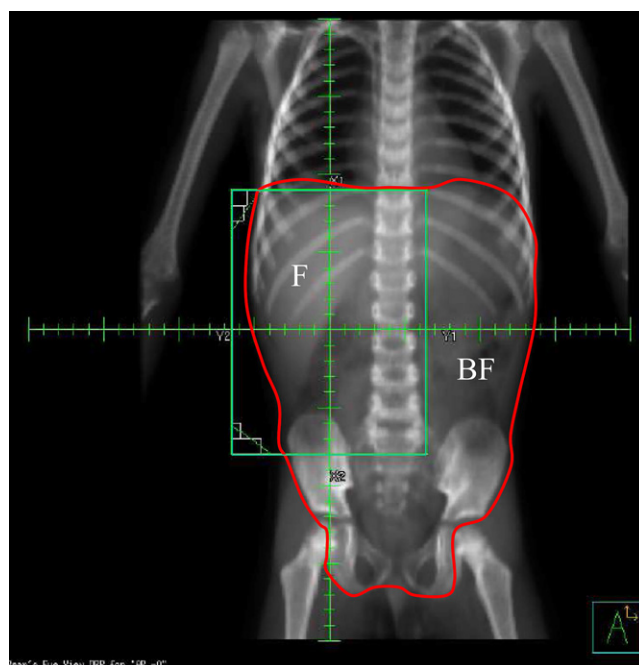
Digitally reconstructed radiograph of a child receiving flank irradiation for a right-sided Wilms tumor. The regions at risk for relapse after spillage, flank (F) and beyond-flank (BF), as defined by radiation fields are shown.
